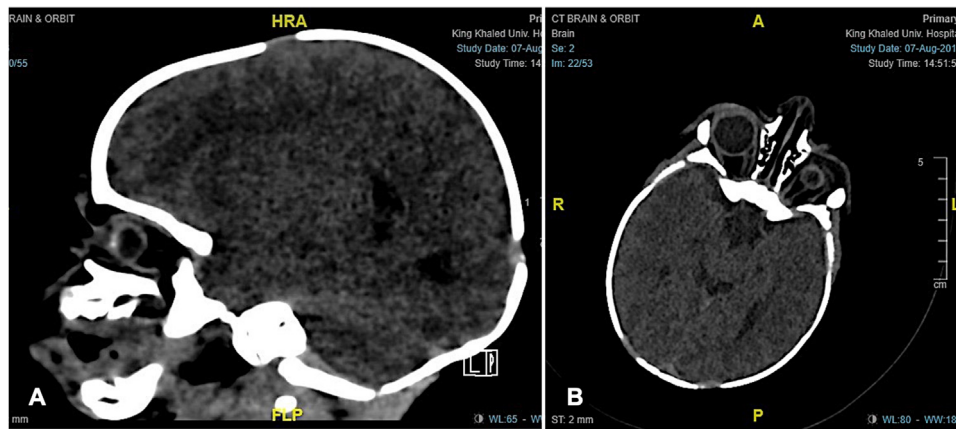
A: A sagittal computerized tomography (CT) scan of the brain and orbits showing a very small left globe with anteriorly located opacification of the retroretinal cartilaginous choristoma. B: An axial CT scan of the brain and orbits showing normal size right globe and microphthalmic left globe with thin connective tissue stalk where the optic nerve is expected to be present.
